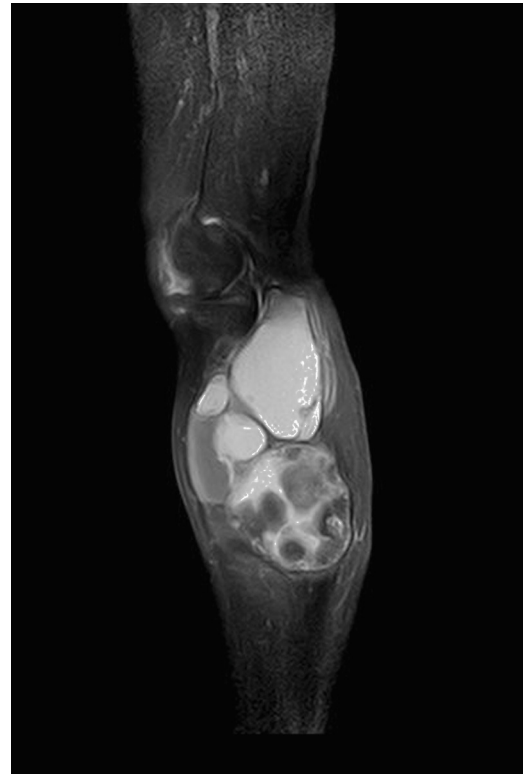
MR. Sagittal T1-weighted image with fat saturation. Peripheral potentiation is observed compared to the precontrast image but no significant image central enhancement, indicating its cystic nature.
